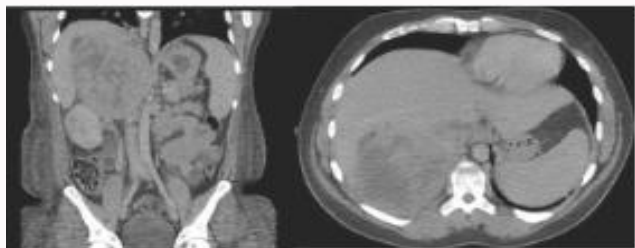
Cross sectional imaging demonstrating change in appearance of large right-sided adrenocortical cancer during chemotherapy with mitotane, CT appearance at the time of initial presentation.
